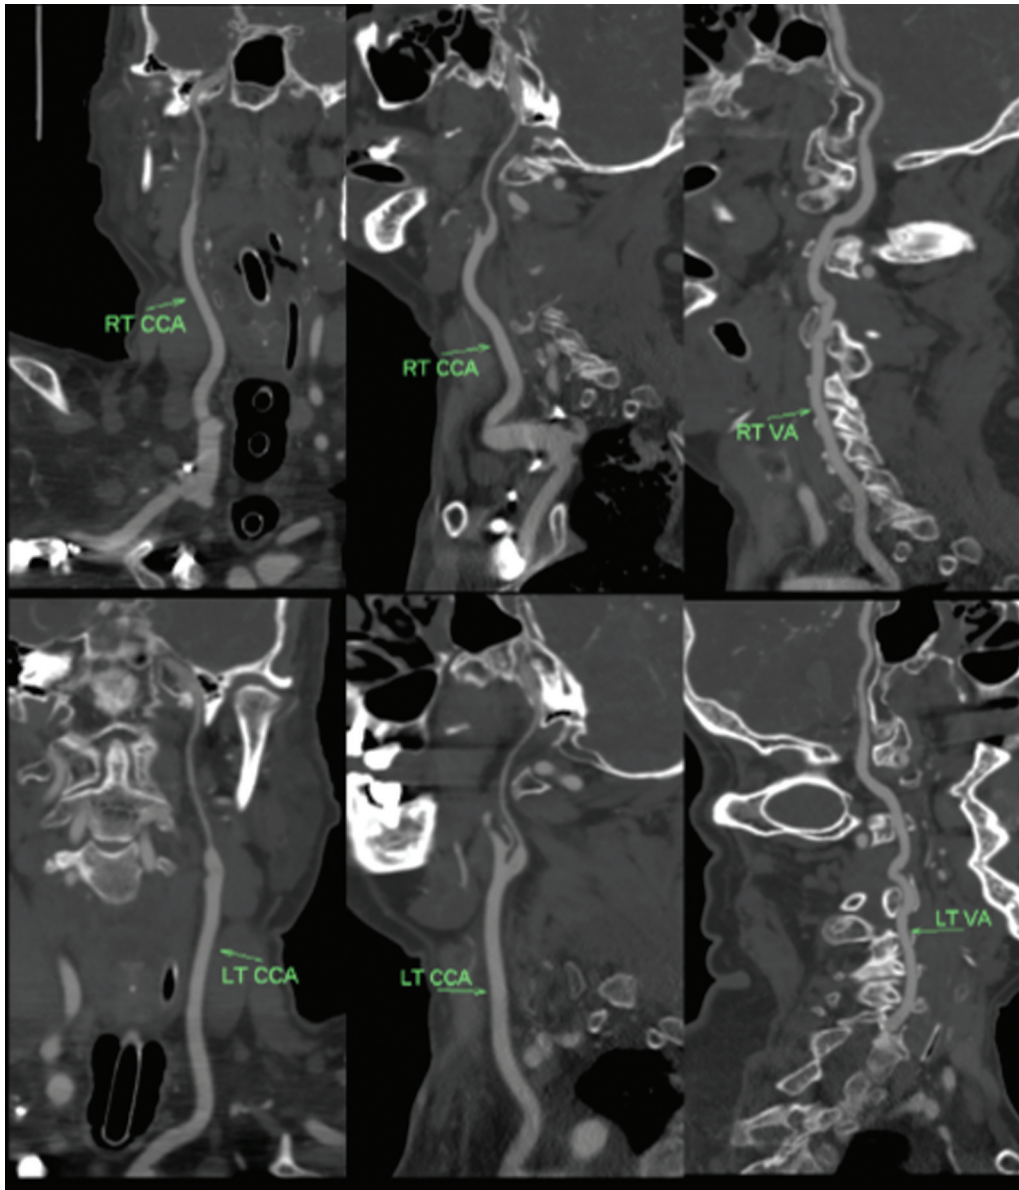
Computed tomographic angiography of neck showing bilateral congenital hypoplastic internal carotid artery as compared to diameter of bilateral vertebral artery.
